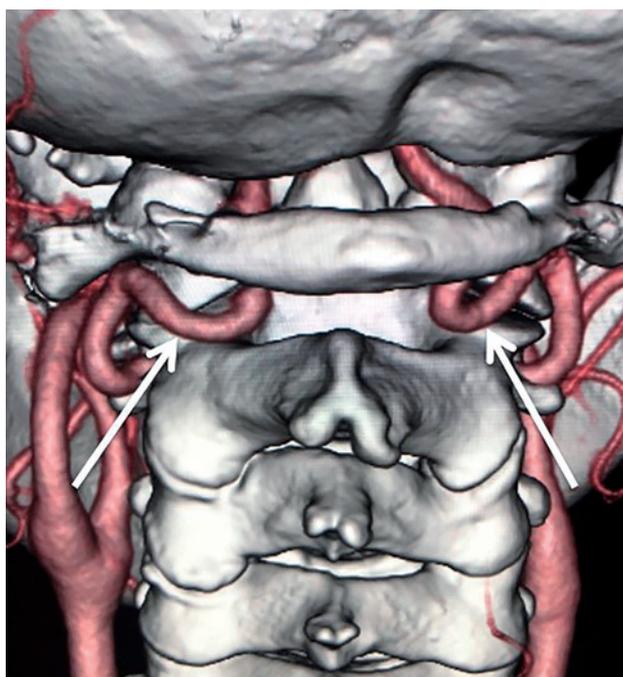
Posterior view on three-dimensional computed tomography angiography showing bilateral persistent first intersegmental artery (white arrow).
